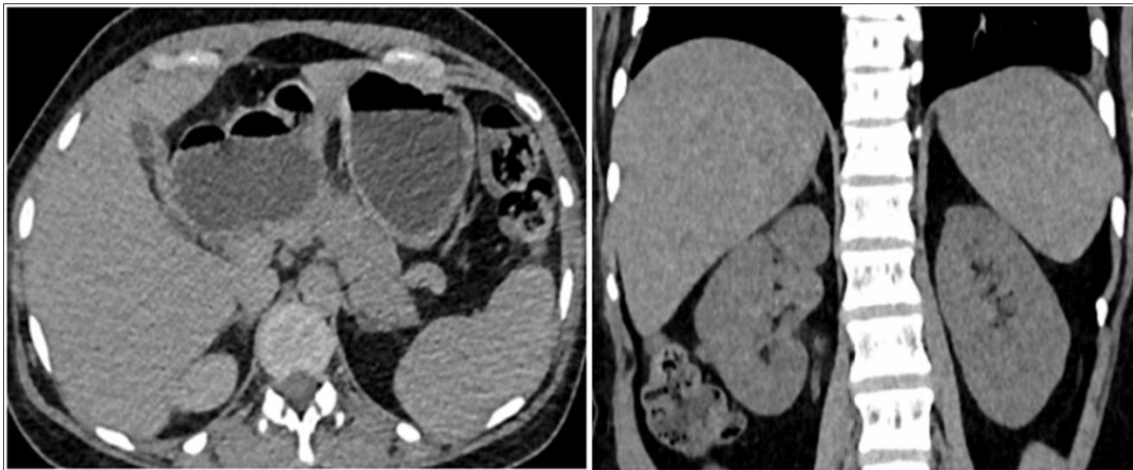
Axial and coronal view of computed tomography (CT) scan abdomen (normal).
